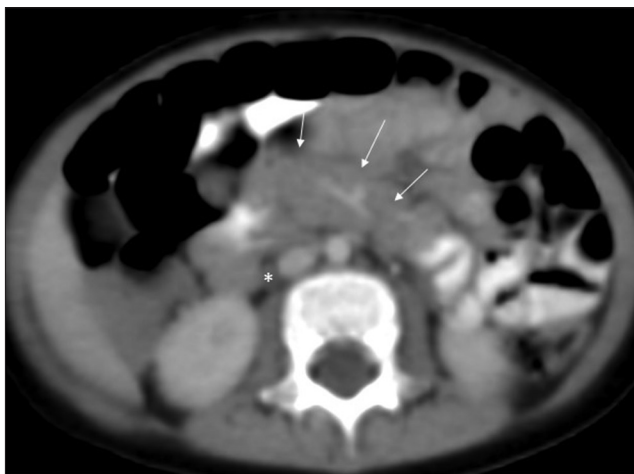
Postoperative transaxial computed tomography, mesenteric/retroperitoneal mass (arrows), prominent right ureter (*)
